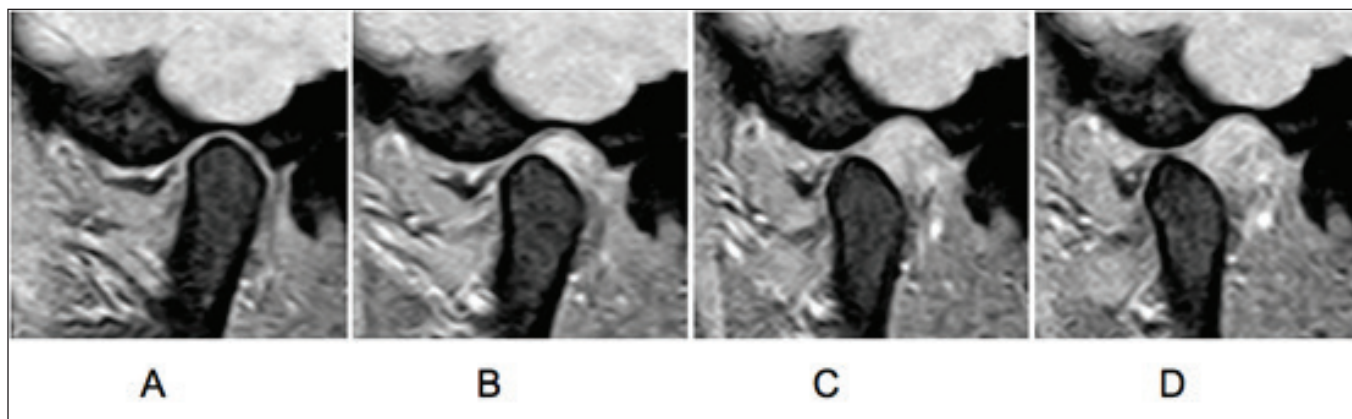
Sagittal MRI of a TMJ classified as “disk displacement without reduction”. The following sequence shows a TMJ at close mouth (A), 10 mm (B), 20mm (C) and 40mm of inter-incisal distance (D). The condyle is unable to recapture the articular disk in the studied dynamic position. This image belongs to a Female 18 years old patient.
